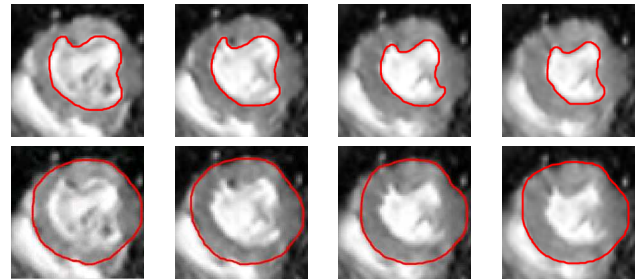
Short-axis view of ENDO- and EPI surfaces from MRI images during ventricular systole. Top: ENDO, Bottom: EPI.
